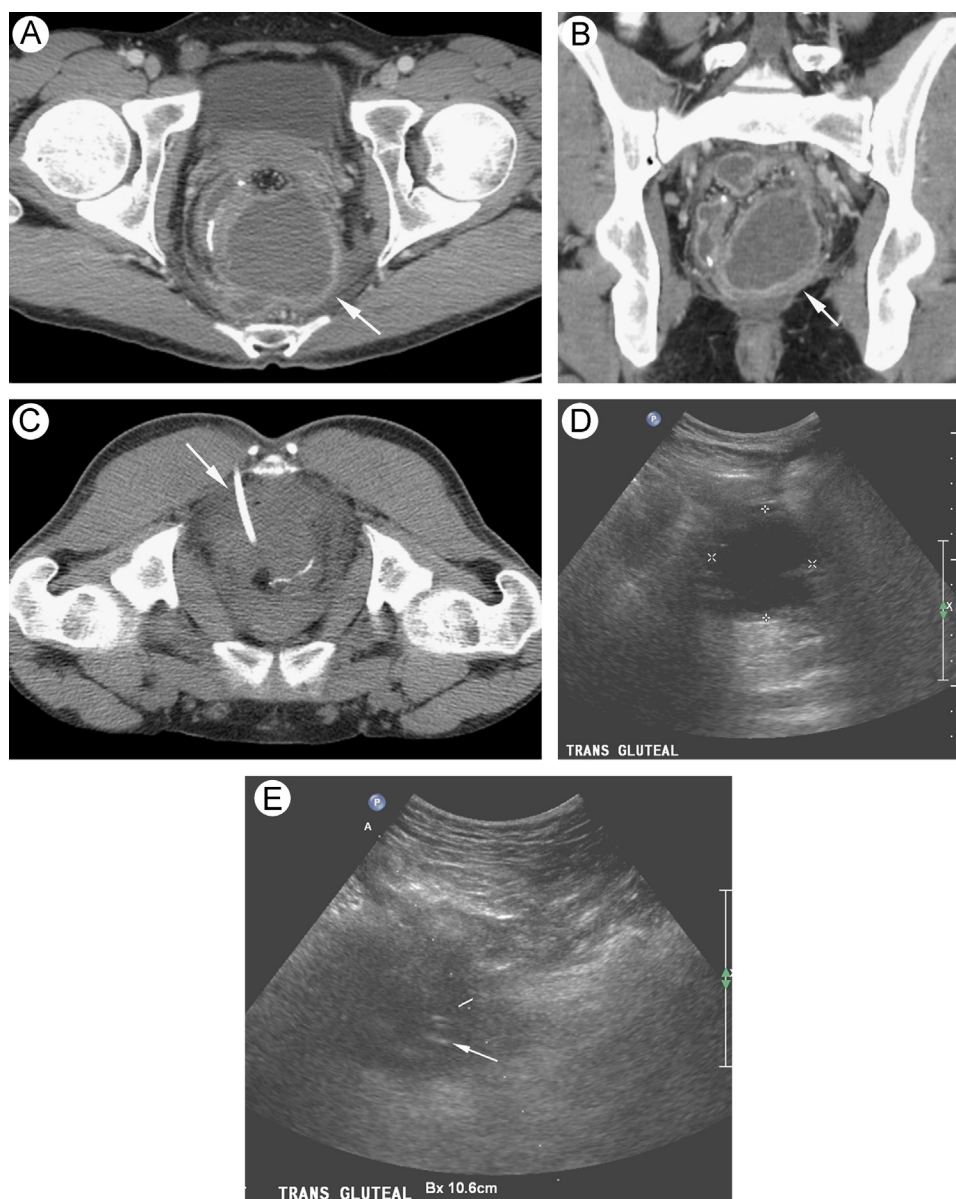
Axial (A) and coronal (B) CT images in a patient with Crohn's disease following IPAA demonstrate a perirectal abscess (white arrows). The abscess was drained under CT guidance (C); note the close positioning of the catheter to the sacrum (white arrow). The abscess recurred 2 months later (D) and the patient underwent US-guided drainage (E). (Color version of figure is available online.)
